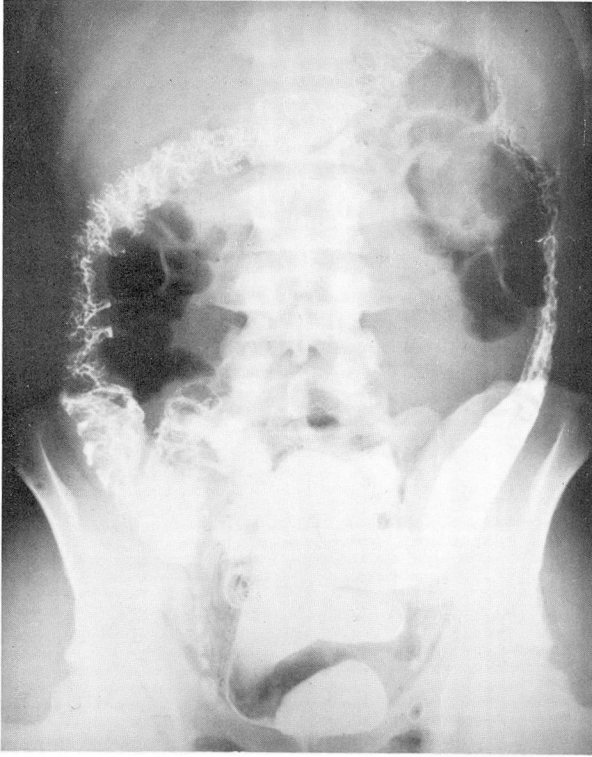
Roentgenogram after barium enema, showing normal structures.
